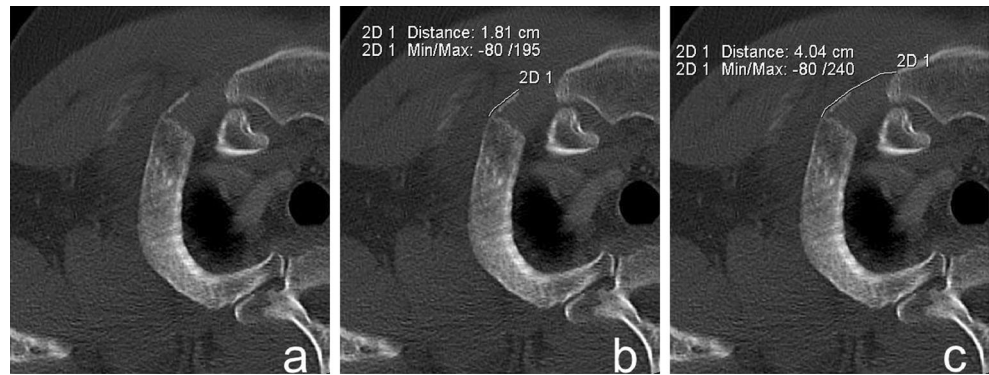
The CT image of the earliest cartilage stage (stage 0) (SIEMENS Syngo MultiModality Leonardo Workplace, bone window, multi planar reconstruction—MPR, oblique plane adjusted to the plane of the first cartilage)
